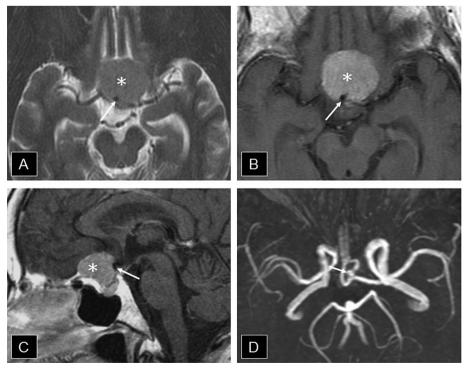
(A) Axial T2-weighted, and (B) axial and (C) sagittal T1-weighted contrast-enhanced images, and (D) magnetic resonance angiography revealed a 2.5-cm homogeneous enhanced mass over the tuberculum sellae (*), with an intratumor vascular pouch from the anterior communicating artery (arrow).
